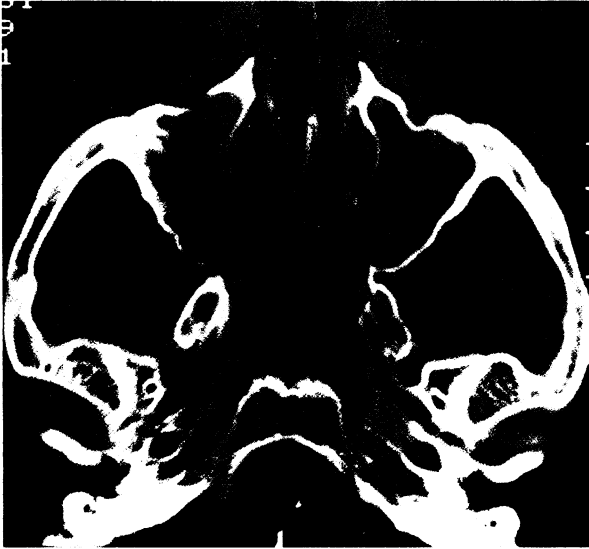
CT scan of inverted papilloma of right nasal cavity and nasopharynx.
